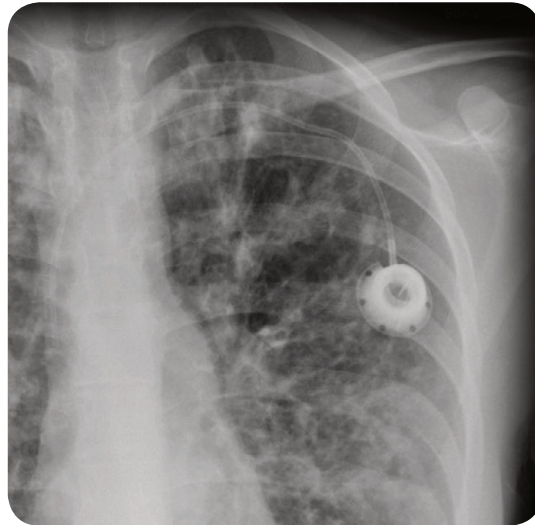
A plain chest radiograph demonstrating tram-track opacities and ring shadows in an individual with cystic fibrosis. They are particularly well demonstrated in the left upper zone.
